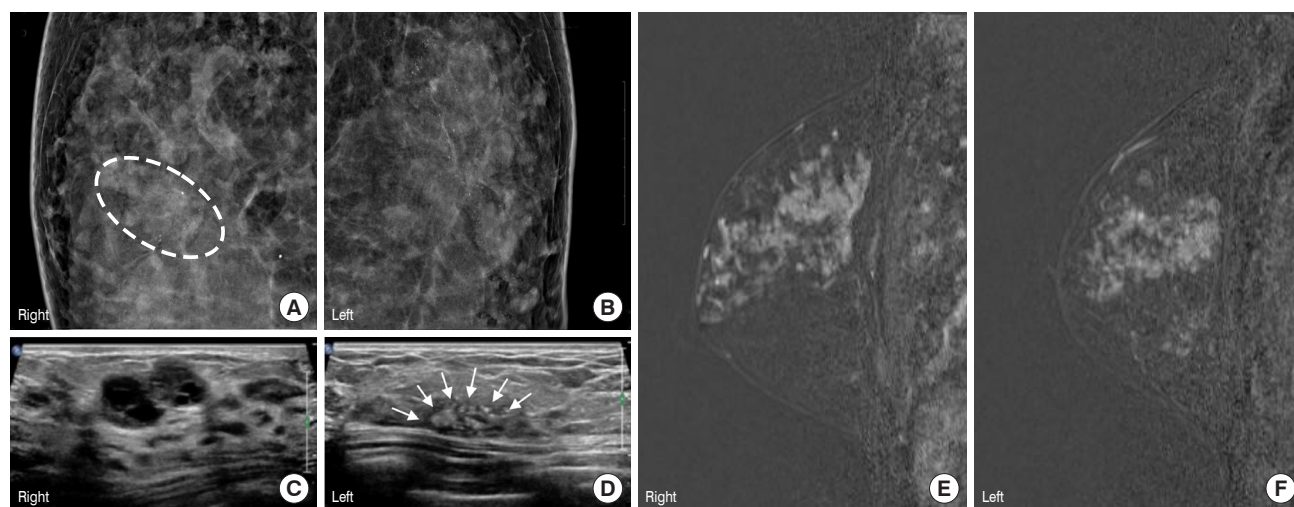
Mammography showed 17-mm sized, lobulated nodule with tiny calcification at upper central portion of right breast (A, dashed line) and segmental distributed, pleomorphic microcalcifications at left upper outer quadrant (B). Ultrasonography showed that multiple hypoechoic mass lesions in right breast (C) and microcalcification in left breast (D, arrows). Magnetic resonance imaging showed diffusely distributed, heterogenous, nodular non-mass enhancement, about 9.0-cm size area at both breast upper outer quadrant (E, F).
